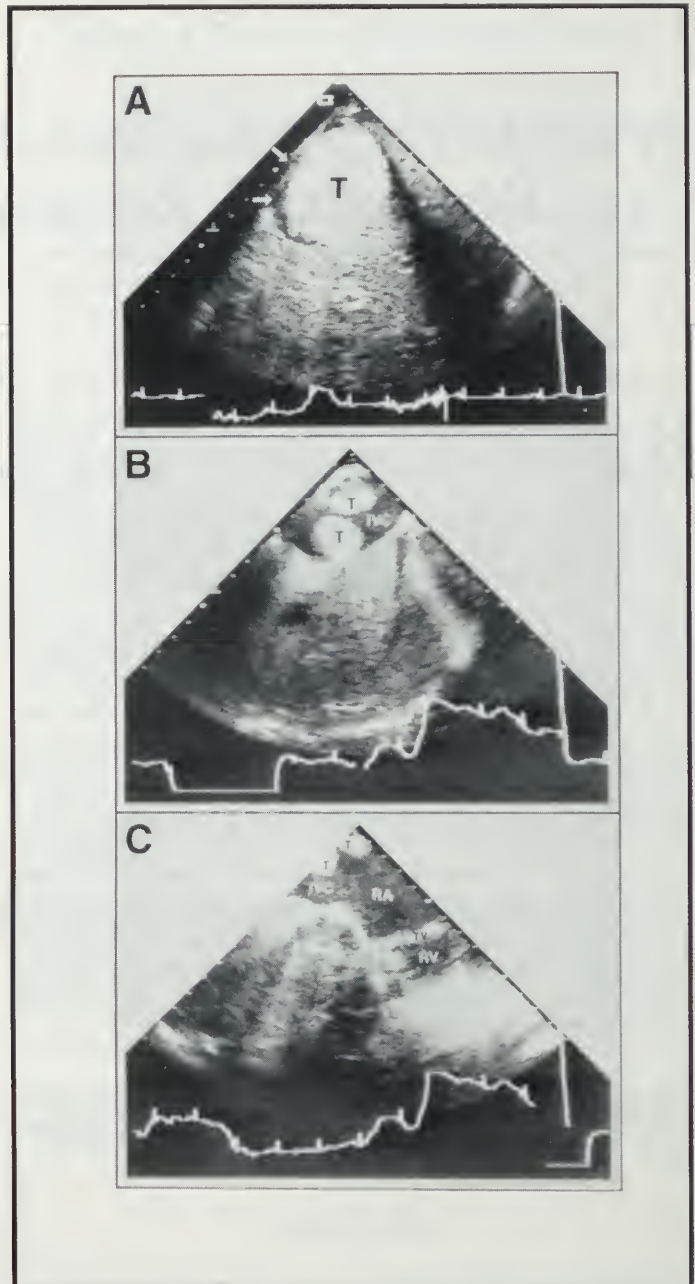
Transesophageal echocardiographic images in the longitudinal plane demonstrating the presence of cavitoatrial extension of renal cell carcinoma. (A) inferior vena cava (demarcated by arrows) with intraluminal thrombus (T). (B) Two tumor-thrombus heads at the most distal level of the inferior vena cava with extension into the right atrium as seen in C. RA = right atrium, TV = tricuspid valve, RV = right ventricle, and IVC = inferior vena cava.
